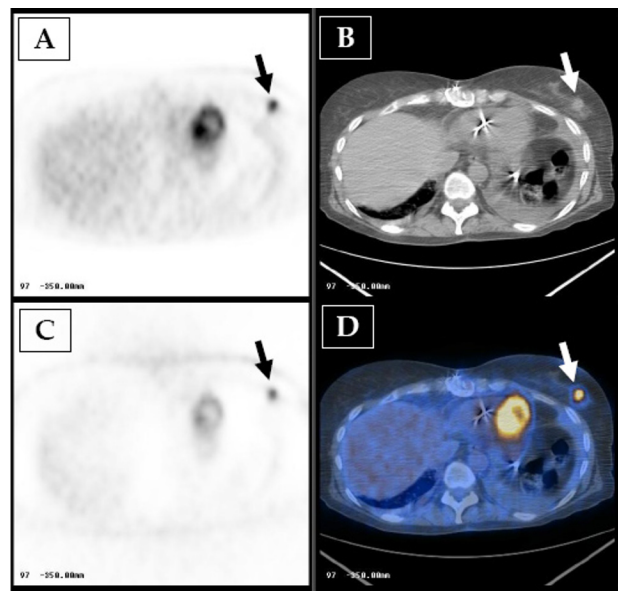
57-year-old woman with incidentally discovered metastatic breast cancer. Axial 18F-FDG PET/CT scans showing an intensely hypermetabolic focus (arrows, SUVmax of 7.7) in the lower lateral quadrant of the breast, corresponding to the primary tumor: A, uncorrected PET image; B, CT image; C, corrected PET image; and D, fused PET/CT image.
